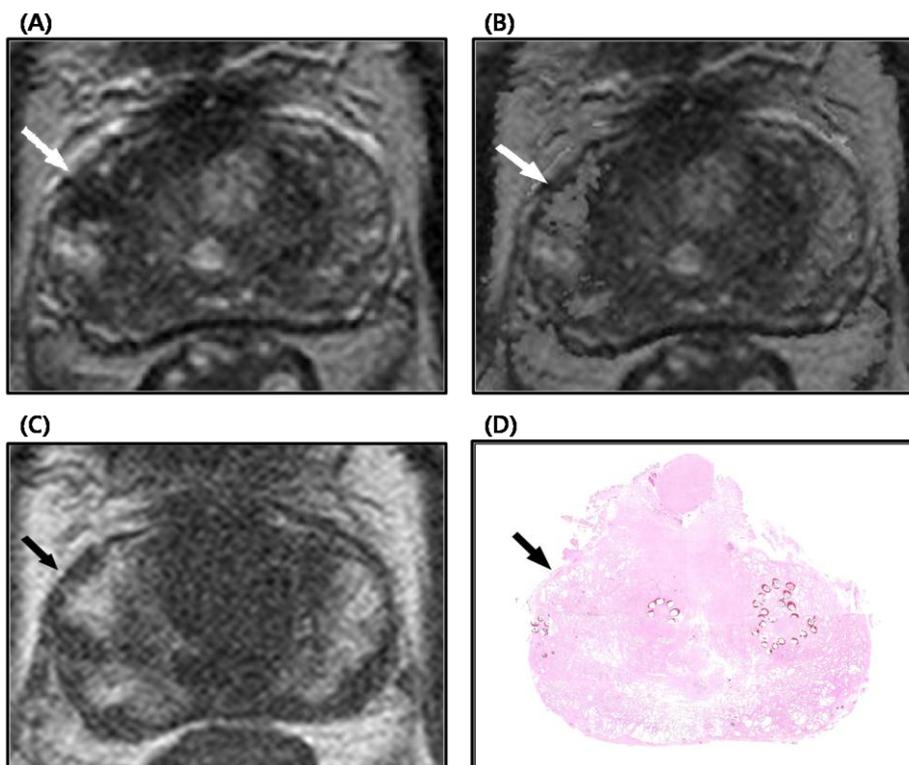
High specificity on T1/T2 registration MR imaging in 74-year-old man with prostate cancer
